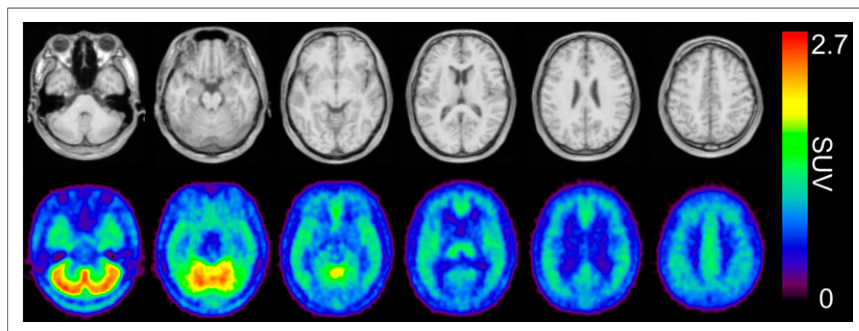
Representative MR and mean static images of ^{11}C -ITMM PET obtained from 5 healthy human subjects. Both images were anatomically normalized using diffeomorphic anatomic registration through exponentiated lie algebra (DARTEL). (Upper) MR image. (Lower) Averaged ^{11}C -ITMM PET image (SUV summed 40–60 min; $n = 5$). PET images were smoothed with gaussian filter of 4 mm in full width at half maximum.
